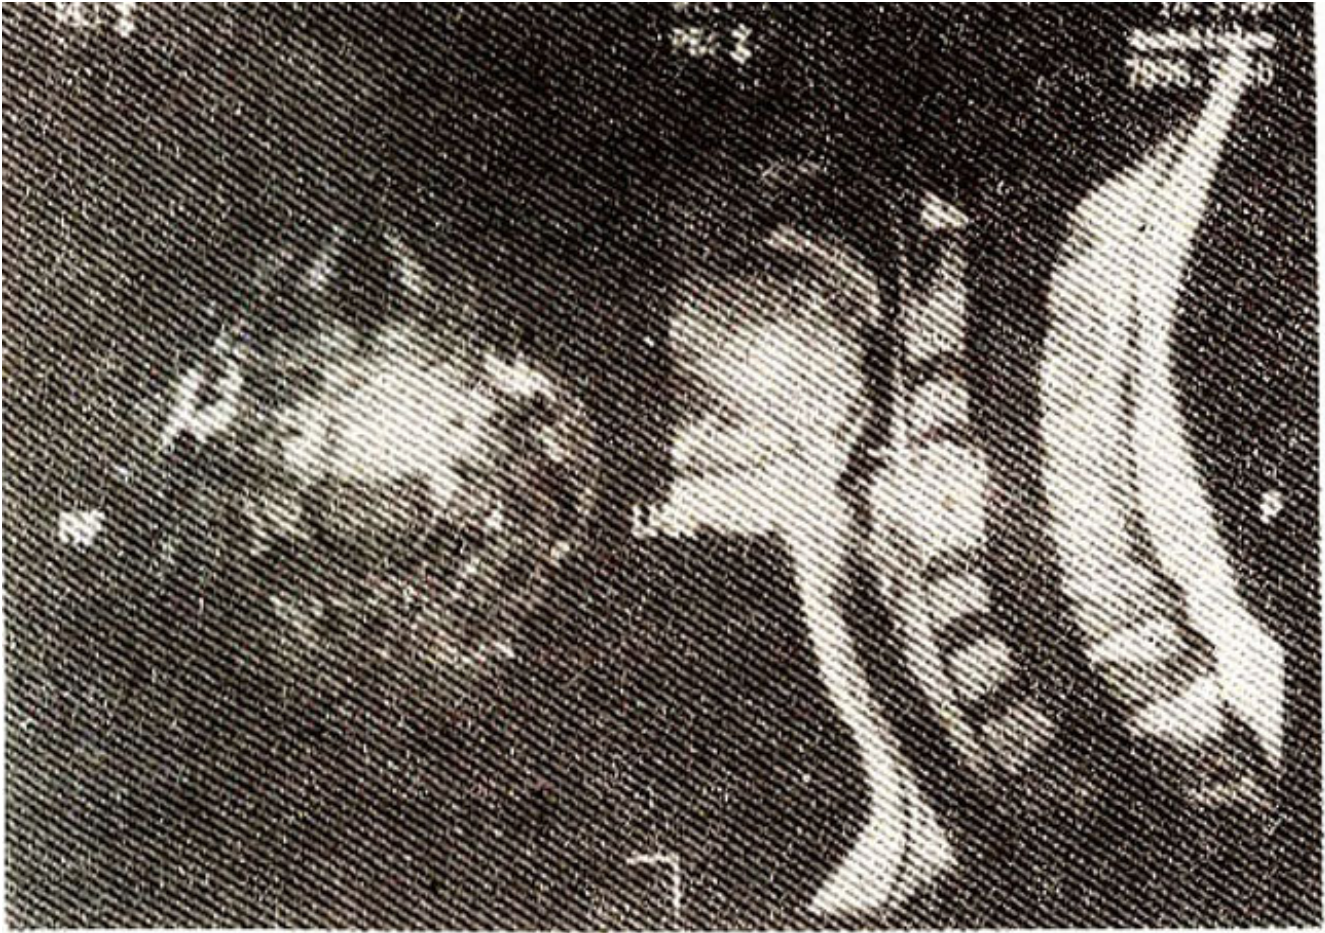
Gadolinium enhanced T-1 weighted MRI images of the cervical spine. The left panel shows axial sections through C4, highlighting the contrast enhancing inflammatory tissue in front of the vertebral body. No compression of the spinal cord is seen. The right panel shows a sagittal view of the cervical spine. Note the contrast enhancement of the C4 and C5 vertebral bodies and the prevertebral and the epidural inflammatory tissue (arrow). No spinal cord compression is seen.
